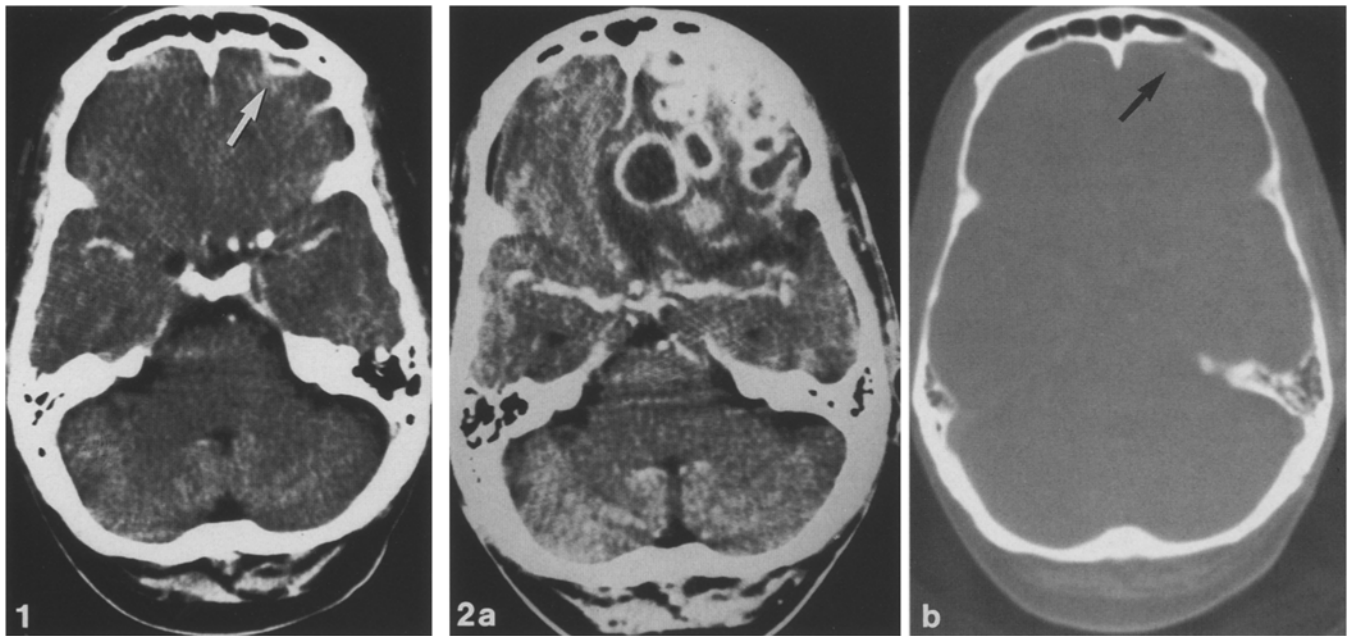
Cranial CT after contrast injection. Small ring-enhancing lesion close to the left frontal sinus (*arrow*). See text
